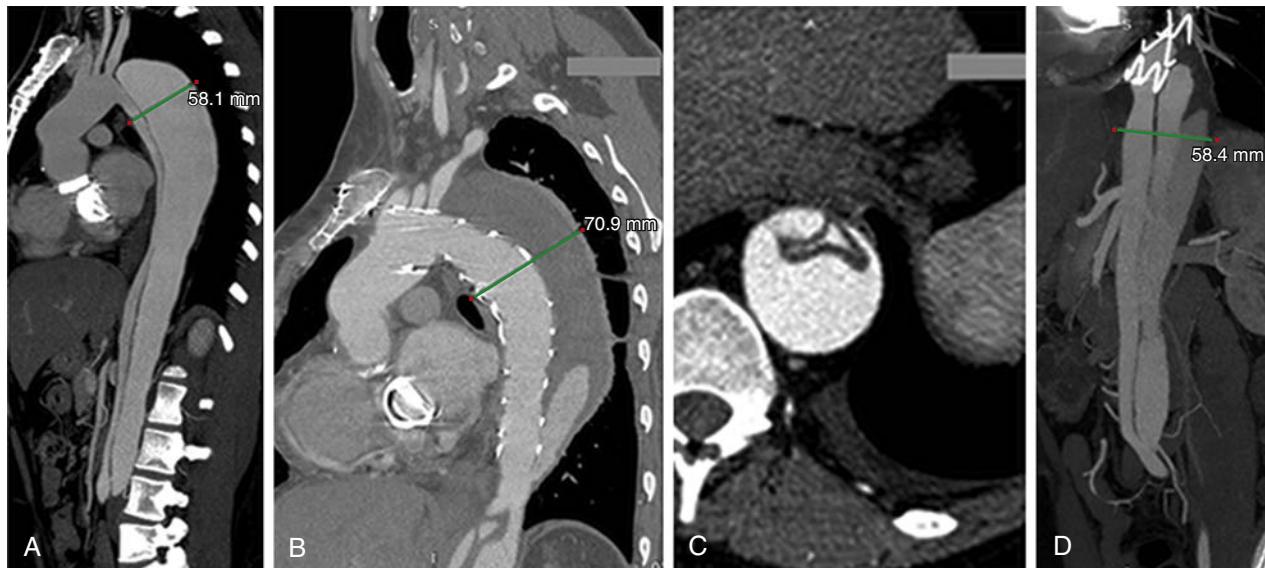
Progression of aneurysm in a patient with Marfan syndrome after thoracic endovascular aortic repair. (A) Initial stent-graft placement. (B) New distal entry tear caused by stent-graft edge seen on 1-month CT scan. (C) New presentation at 4 months with acute back pain and near-circumferential dehiscence of the intima media. The patient was treated medically until 6-month CT scan revealed (D) new progression to thoracoabdominal aortic aneurysms, which led to referral to the author for repair.
